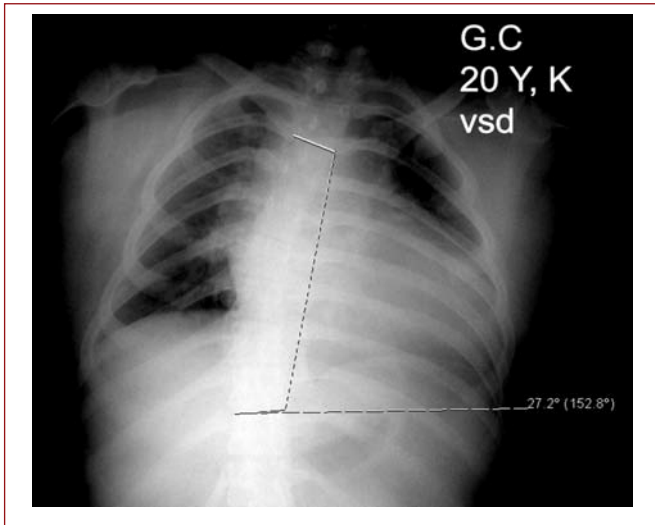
27.7° of scoliosis visible by thoracic X-ray in a 20-year-old female patient with ASD.
